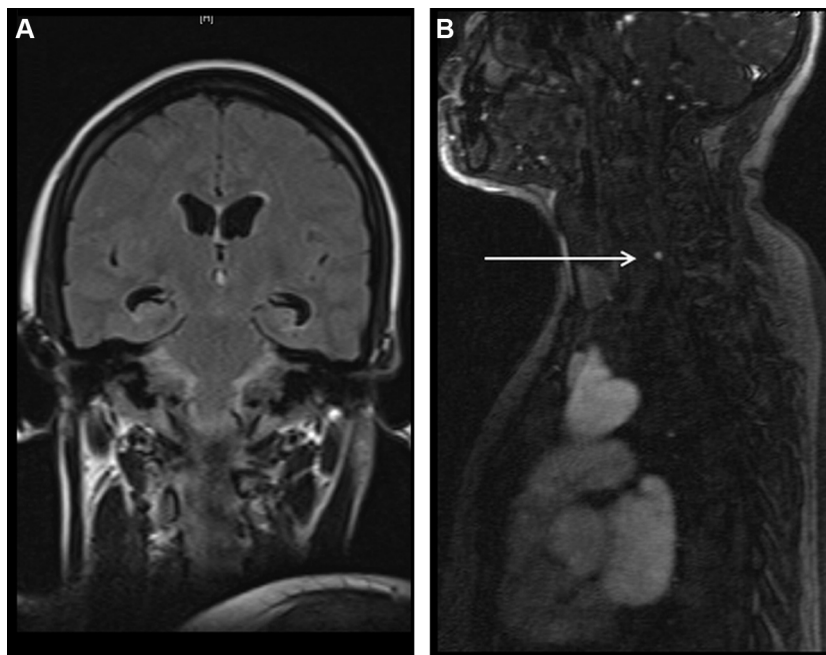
A. Initial cerebral MRI showing the subarachnoid haemorrhage in the posterior fossa with no visible intracranial vascular lesion. B. Initial medullary MRI after gadolinium injection showing an enhanced formation in front of the posterior part of C6 vertebral body.
